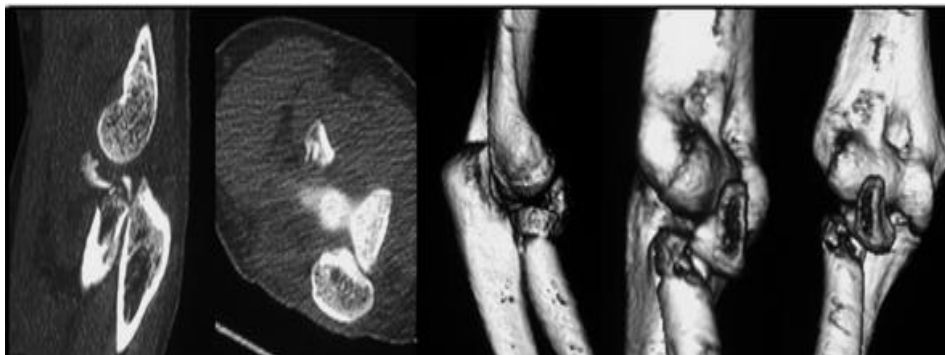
Pre Operative CT Scan Images showing Radial Head Fracture with Displacement
